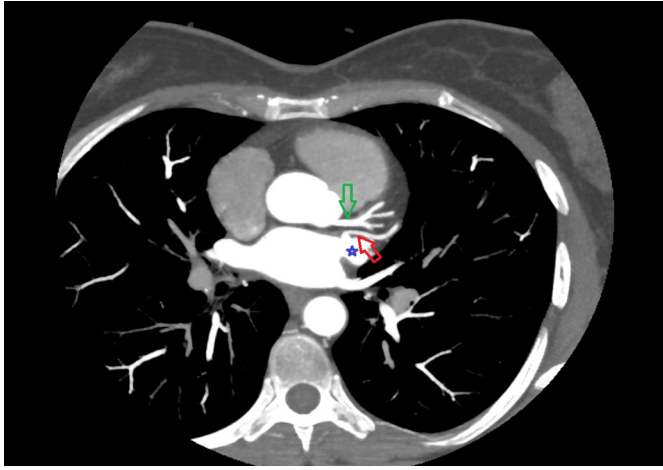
Case 1. Axial CT image. Blue star: LAA; red arrow: GCV; green arrow: left main coronary artery
